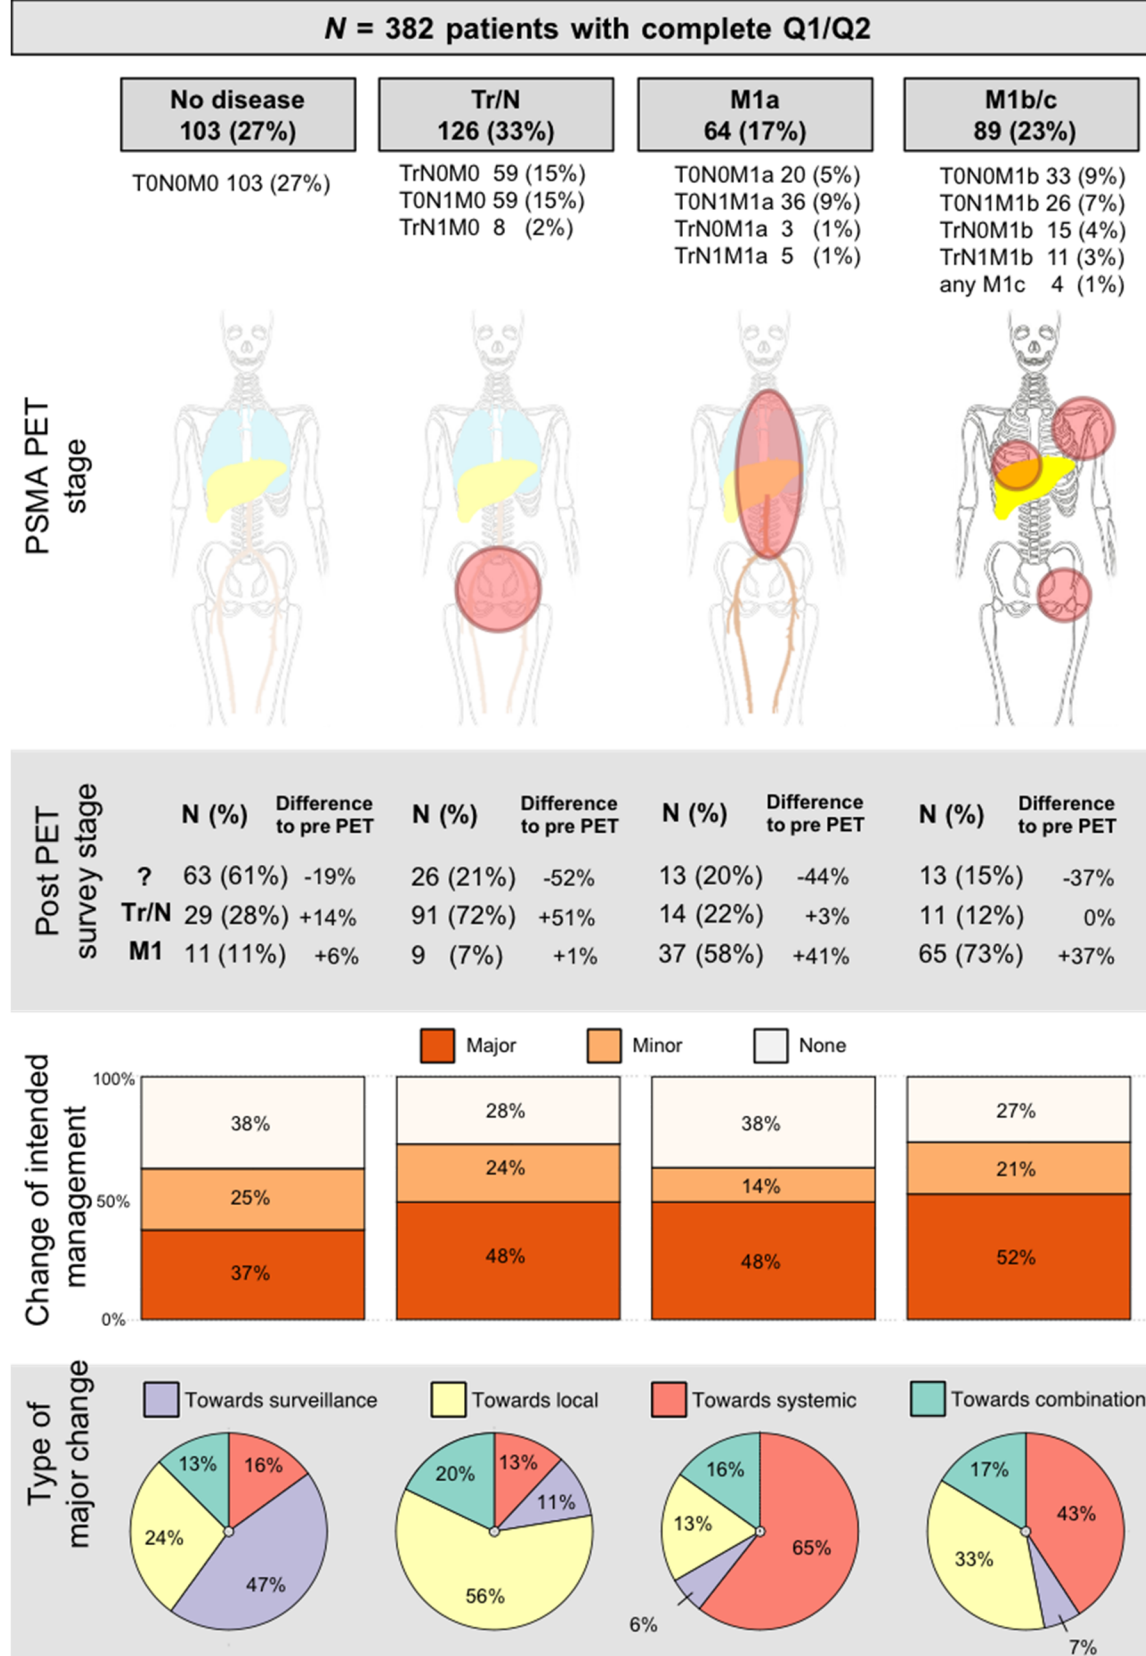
Summary of intended management change after PSMA PET. Abbreviation: ?, unknown stage.
